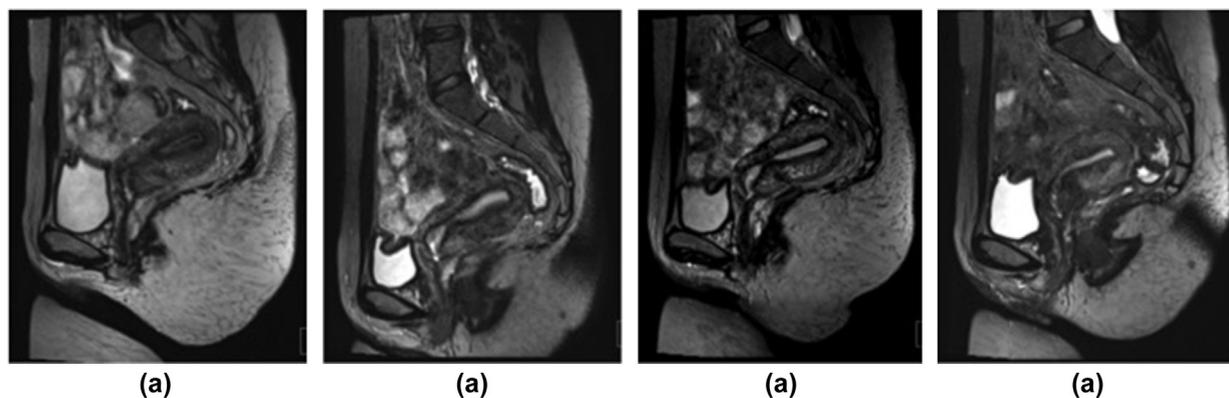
High-resolution 3D T2-weighted images in the mid-sagittal plane of a 34-year-old volunteer during the menstrual cycle including (a) MP; (b) FP; (c) OP; (d) LP. OP exhibited the clearest boundary sharpness of the uterine zonal structures, following by FP, LP, and MP.
